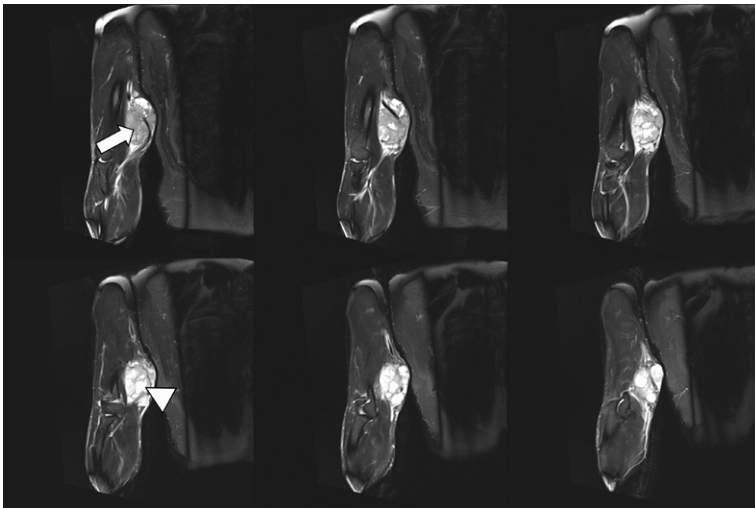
1.5-T MRI of the arm (proton density [PD] fat saturation [FS]): 6 consecutive slices of 3 mm) of a 54-year-old patient. The higher-grade polycyclic/multilobulated sarcoma in the upper arms shows solid (white arrow) and cystic (white arrowhead) components.
